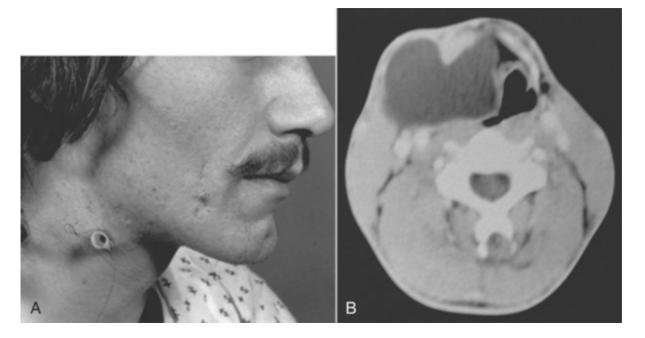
A, Patient with an infected second branchial cleft cyst treated by incision and drainage and insertion of a Penrose drain. B, Computed tomography scan of the patient in A.
